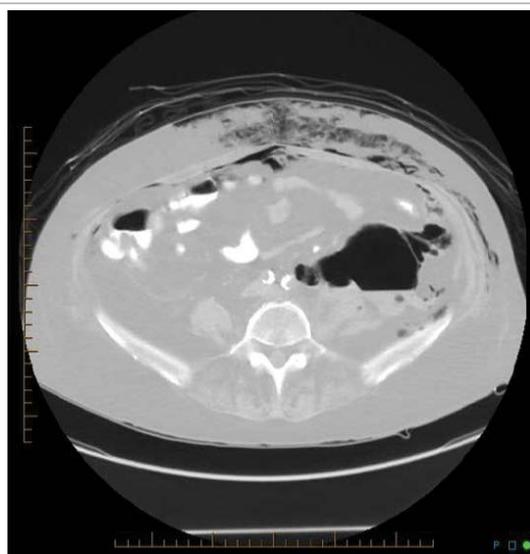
Non-contrast computed tomography scan of the abdomen. Coronal view showing significant subcutaneous emphysema with focal areas of pneumoperitoneum.
